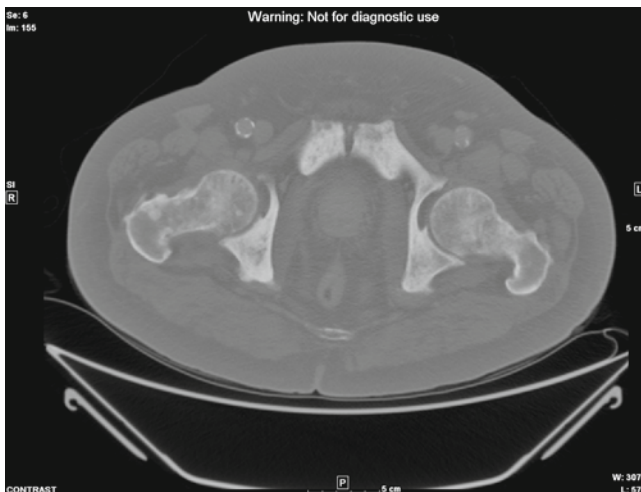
Non-enhanced axial CT through the pelvis on bone windows demonstrates extensive sclerotic metastases throughout the pelvis
